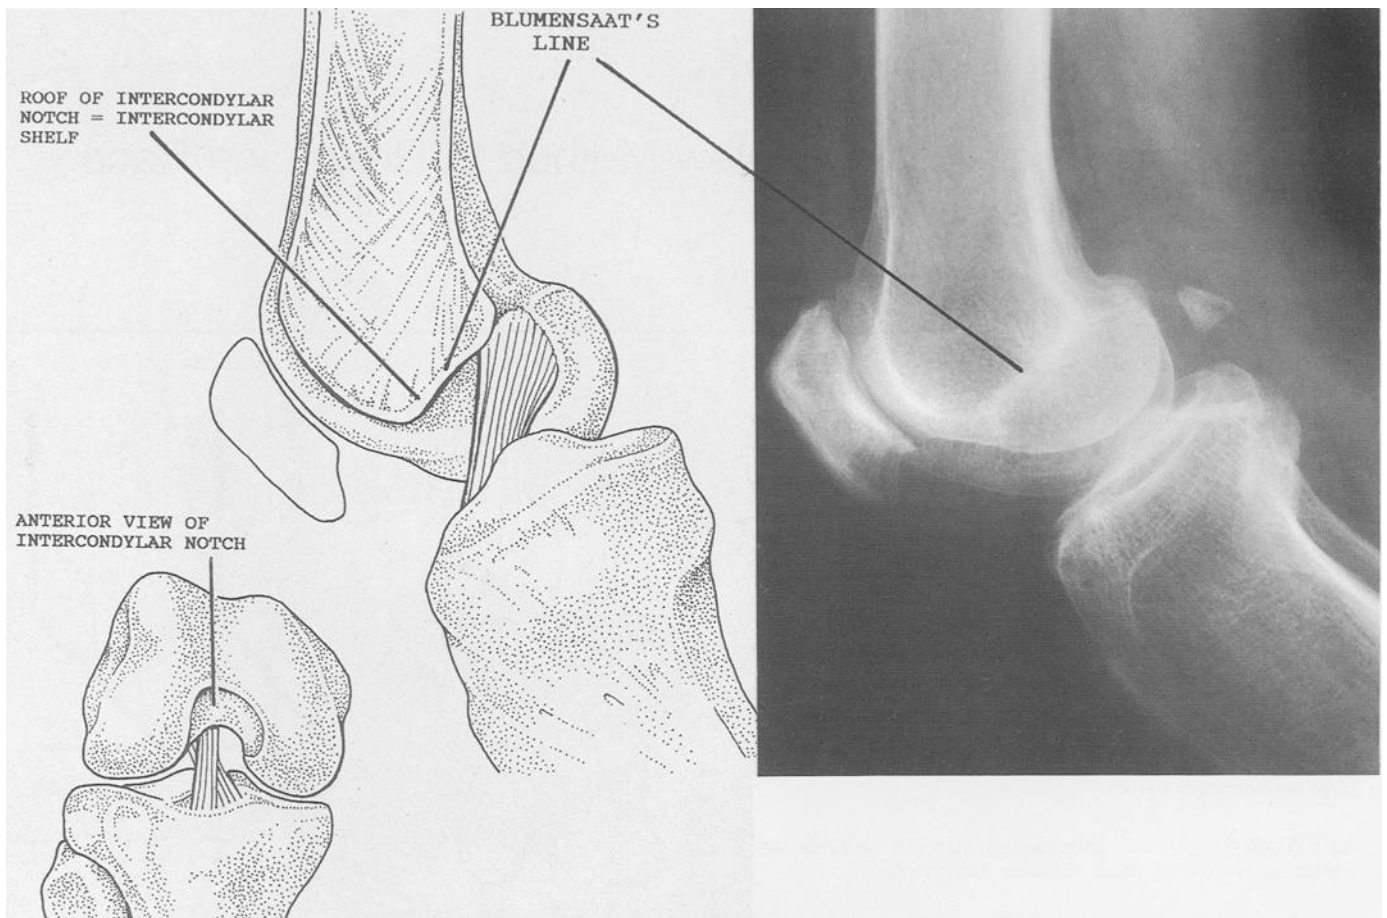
Lateral radiograph and sagittal section show the anatomy of the intercondylar shelf in relation to the intercondylar notch.
